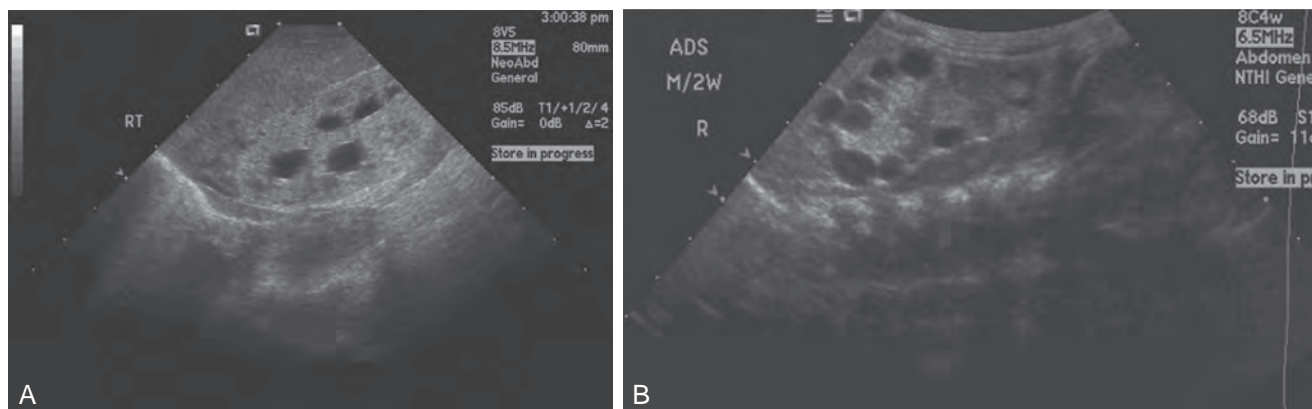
Ultrasonographic appearance of renal dysplasia. A, Classic dysplasia with hyperechogenic appearance of the kidney relative to the liver, a loss of normal corticomedullary differentiation, and dysmorphic calyces. B, Renal dysplasia accompanied by cysts. (Courtesy Marta Hernanz-Schulman, MD.)
